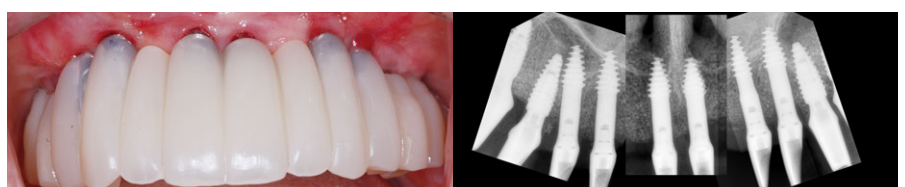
After attaching a TiGEN abutment, a temporary crown was loaded. The abutment attachment was confirmed via intraoral radiographs, and the soft tissue and bone reactions around the implant were satisfactory.
